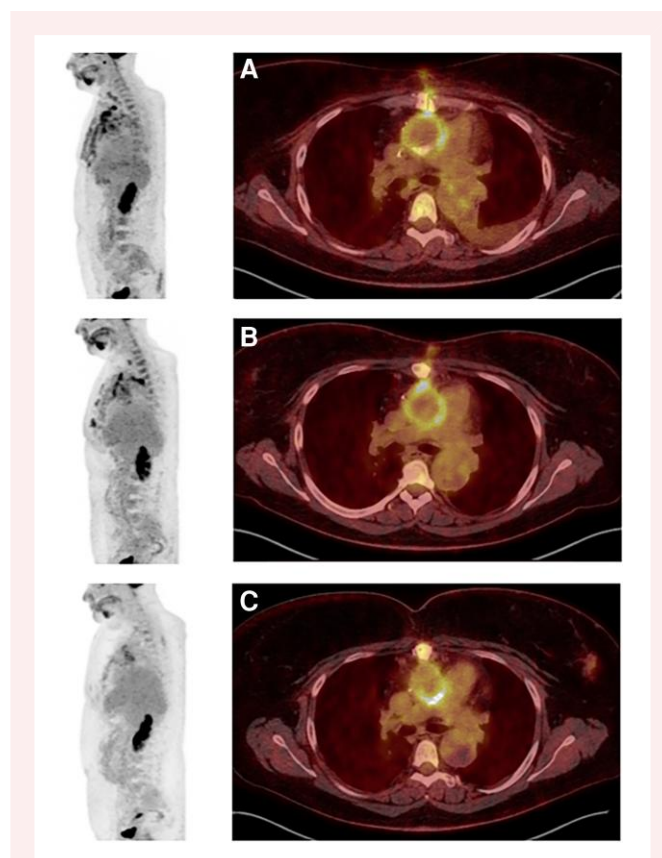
Full body 18F-FDG PET/CT scan (left) and transverse section at the level of pulmonary artery bifurcation (right), after initial antibiotic therapy (A), after multiple courses of antibiotics (B), and at 22 months post aortic graft re-operation (C), showing persistent hypermetabolic activity in (A) and (B), which is largely improved at (C).
